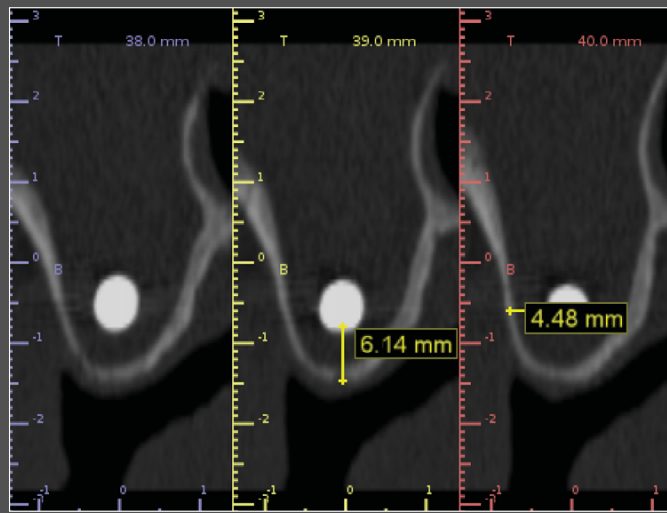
Location of the implant on the CT scan
